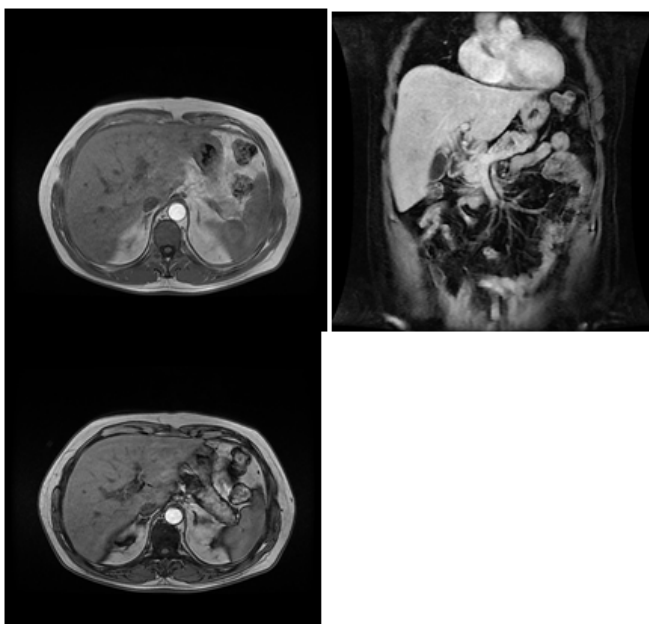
Hepatic magnetic resonance imaging (MRI) which shows harmonious hepatomegaly with hypovascular areas and vermicular aspects.
